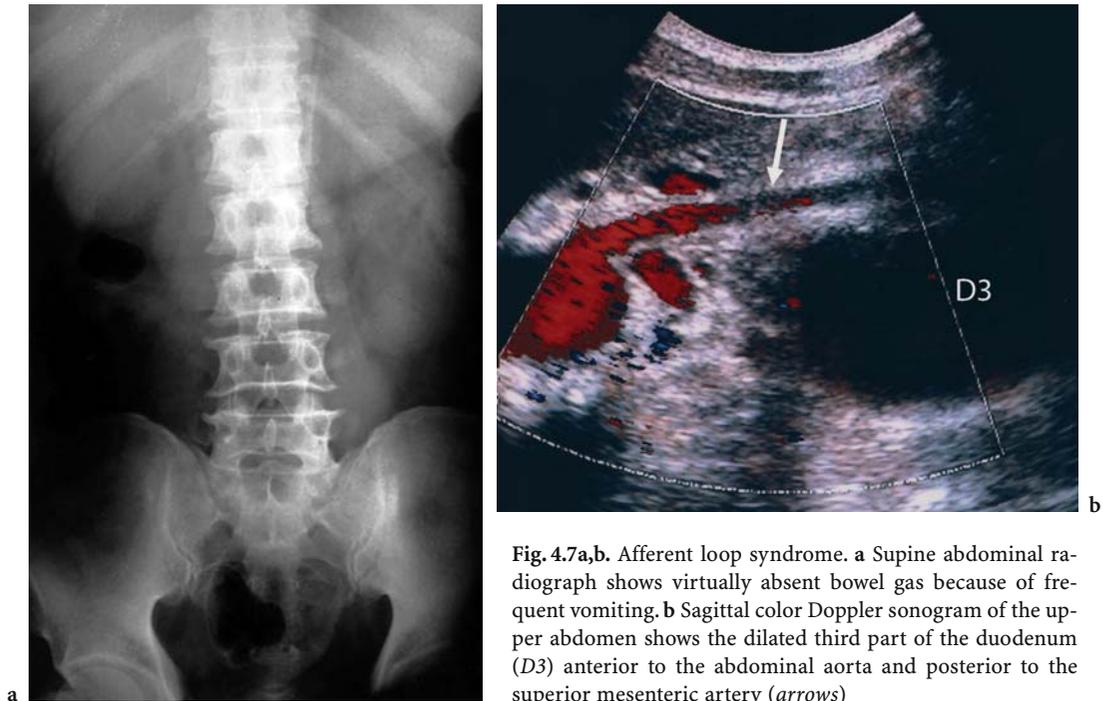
Afferent loop syndrome. a Supine abdominal radiograph shows virtually absent bowel gas because of frequent vomiting. b Sagittal color Doppler sonogram of the upper abdomen shows the dilated third part of the duodenum (*D3*) anterior to the abdominal aorta and posterior to the superior mesenteric artery (*arrows*)
